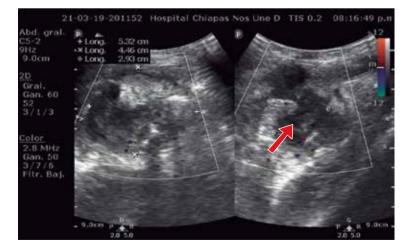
Ultrasonographic imaging shows a liquid collection at the lower right quadrant. The arrow points to the collection.
